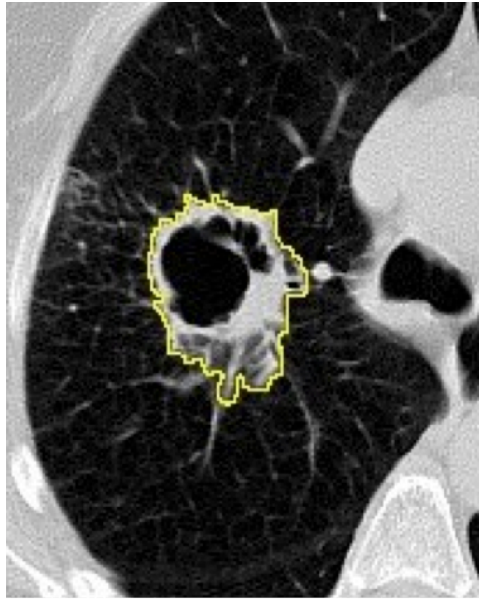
CT scan of lung showing a cancer in the right upper lobe (circled) with regions of necrotic (dead) and viable tissue (Courtesy of Dr. Robert Gatenby).
